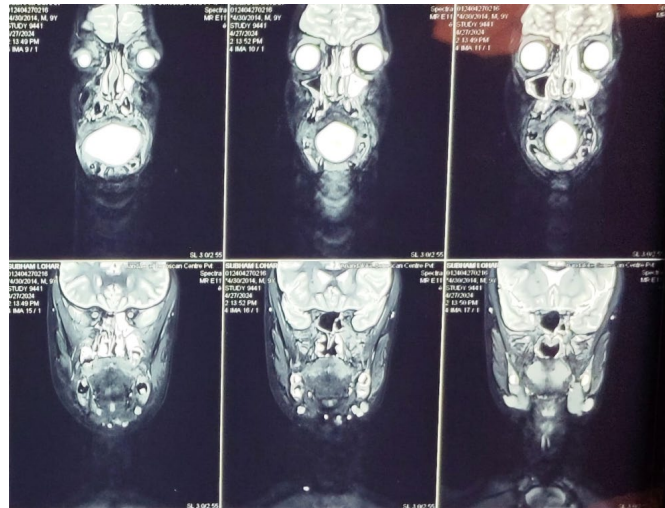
Contrast enhanced MRI showing extent of the cyst
